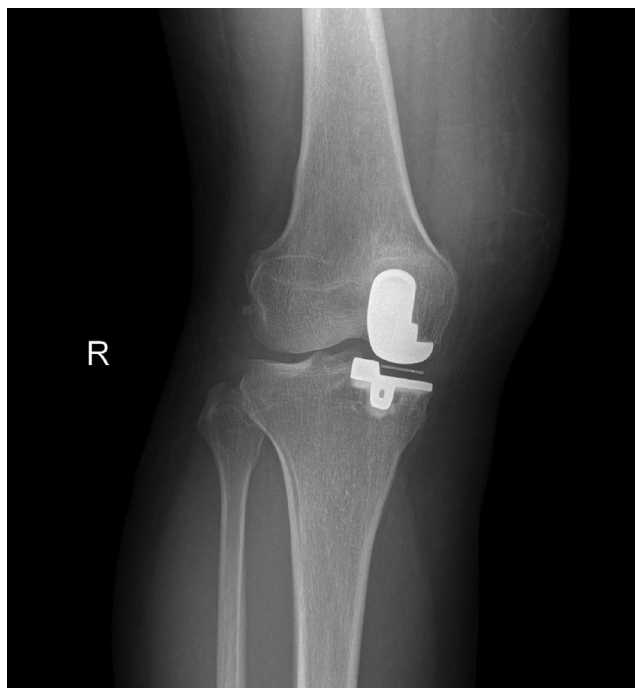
Over-rotated knee X-ray. The thickness of the vertical wall indicates that the knee is rotated in the coronal position.
